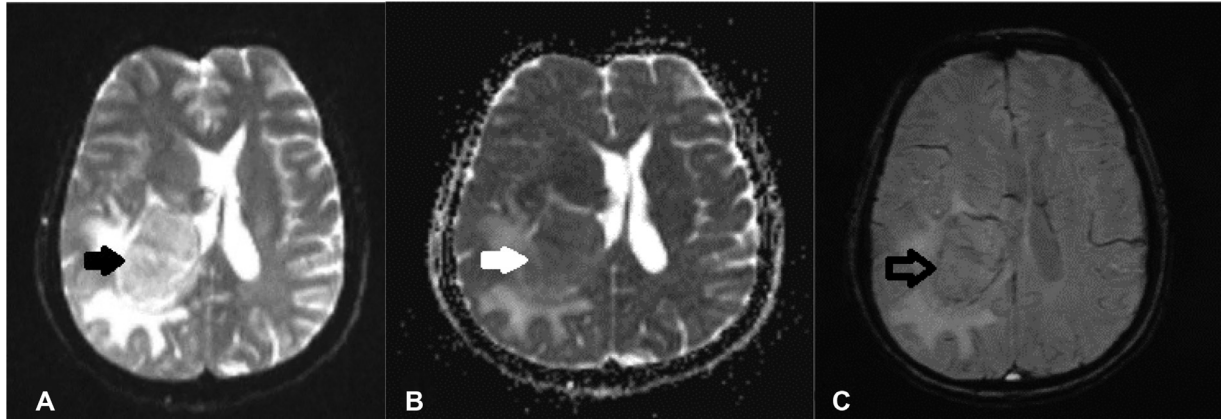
(A) ADC (black arrow) and (B) DWI showed isointense signals with slightly inhomogeneous hyperintense mass, with a few restricted area (white arrow), and (C) SWI forming a “blooming artifacts” (black arrow).
